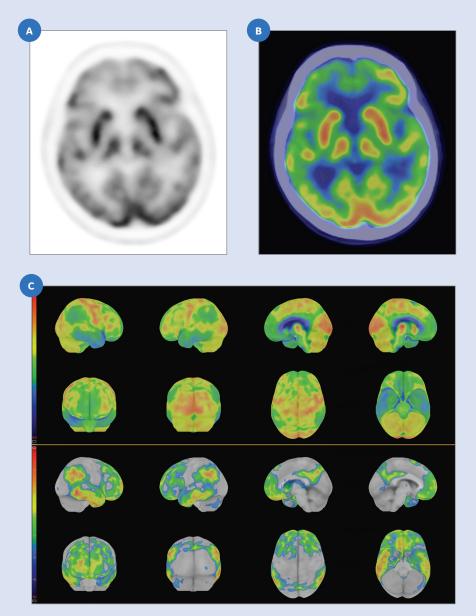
(A) PET only image; (B) PET and CT fused image; (C) CortexID Suite application of both SSP projections and Z-score summary.
